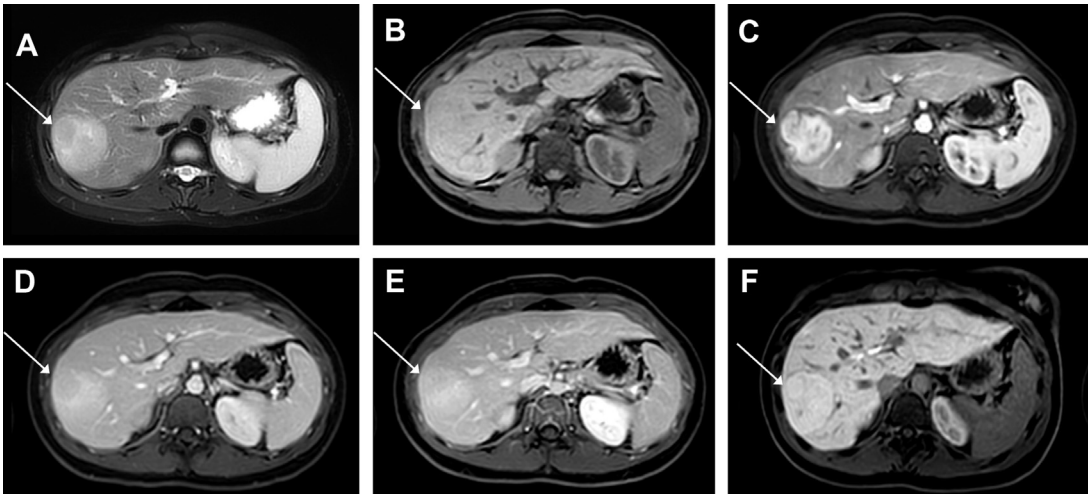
Pitfall of lesion with central element hyperintensity in the hepatobiliary phase. Focal lesion slightly hyperintense on T2-weighted fat-saturated image (A), isointense on T1-weighted fat-saturated image (B), demonstrating arterial hyperenhancement after injection of gadobenate dimeglumine (0.1 mL/kg) (C) without washout in the portal venous (D) or delayed phase (E) with homogeneous uptake in the hepatobiliary phase (F). T2 hyperintensity and minimally heterogeneous enhancement in the arterial phase were not typical for focal nodular hyperplasia. The final diagnosis made through pathology was an inflammatory β -catenin-mutated adenoma.
